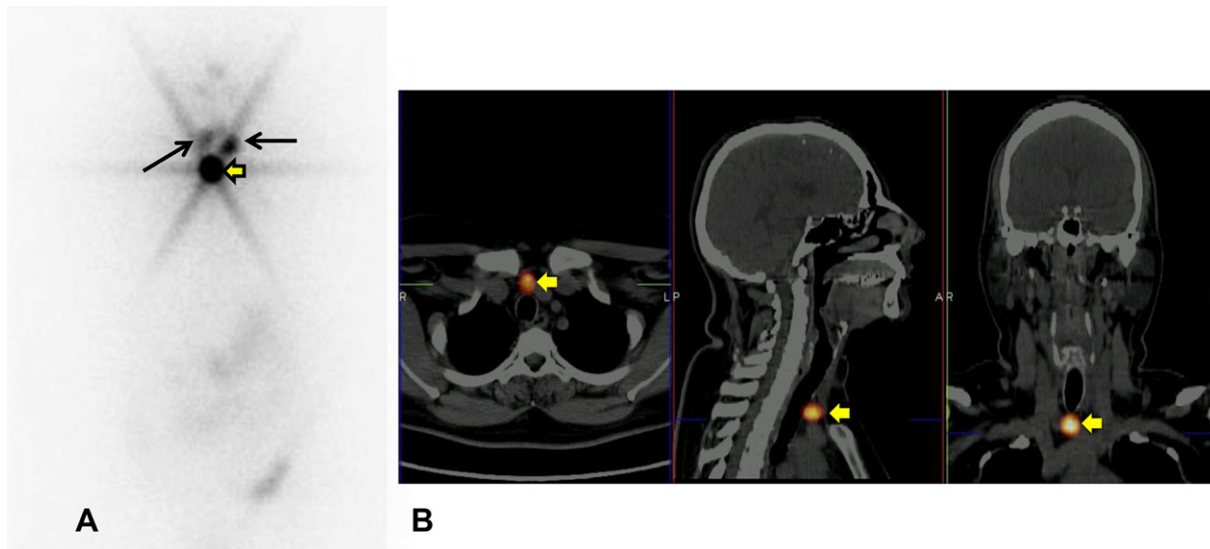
Post-ablation ^{131}I WBS (A) and SPECT/CT (B) in a young female affected by papillary thyroid carcinoma (pT2 Nx) showing remnant tissue within the thyroid bed (arrows) and a central neck lymph-node metastases (yellow arrow head).
